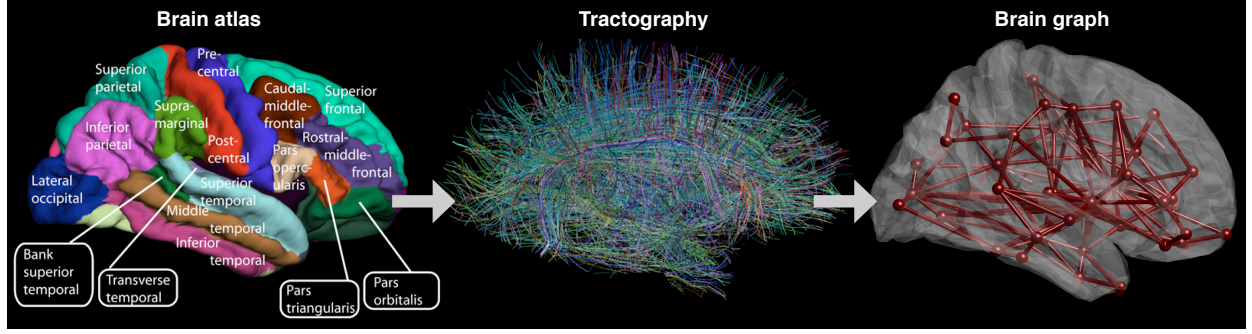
Example brain graphs. Knowledge from an anatomical atlas according to anatomical features such as gyri and sulci (left) is combined with MRI structural connectivity extracted from diffusion-weighted MRI (middle), which can then be used to estimate the brain graph (right). [Adapted from [24]].
